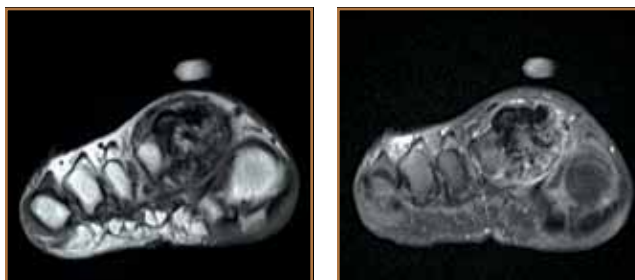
A coronal T1-weighted MRI on the left demonstrating the mass without connection to the medullary canal and a T2-weighted MRI without any medullary edema on the right.
